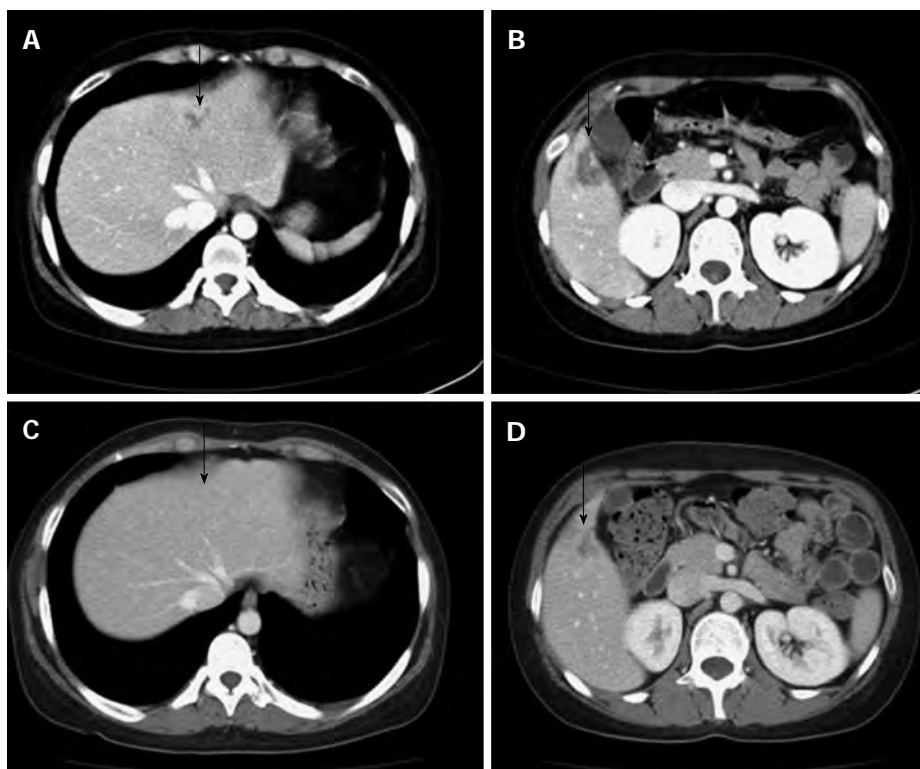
Recurrent and nearly complete resolution intraparenchymal hemorrhage in the liver (arrows). A, B: An abdominal computed tomography showed a low attenuated lesion (arrow) in the S2/4 (A) and S5 segments (B) of the liver on the contrast-enhanced image; C, D: An abdominal computed tomography showed resolution of the parenchymal hemorrhage in S2/4 (C) and the healing process in S5 (D) of the liver.
